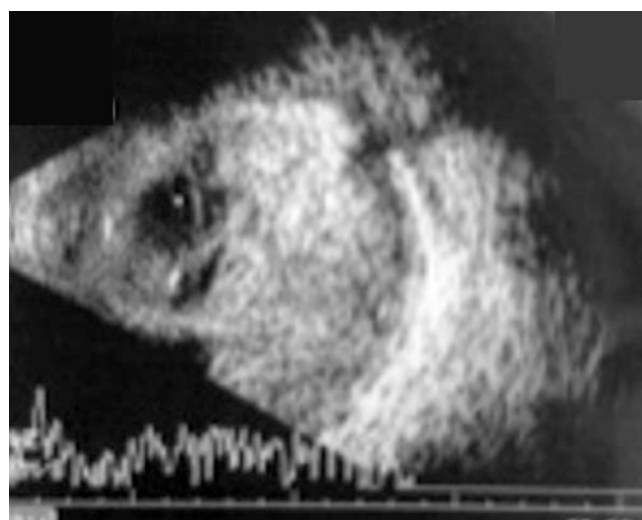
Ultrasound B-scan showing posterior segment mass with high reflective echoes and calcification with intact scleral coat
